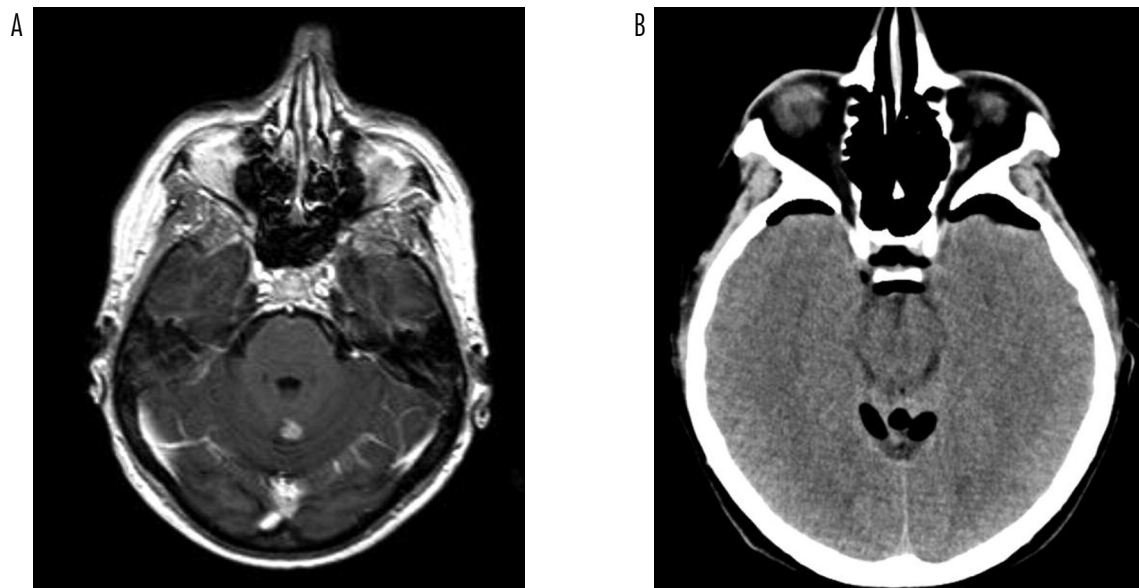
MRI before surgery and intraoperative CT – assessment of tumour removal
